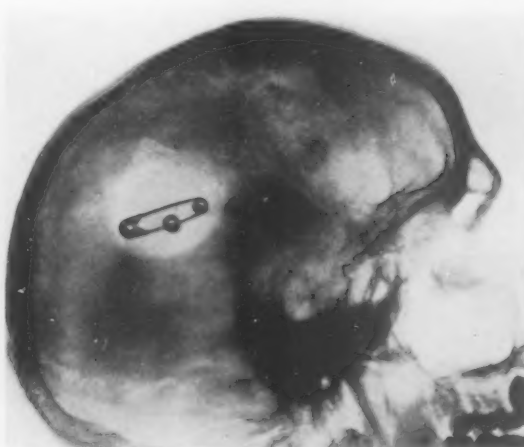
Lateral view nine days after radiographs, Figs. 10 and 11. Very little sodium iodide could be injected. However, when this is compared with the previous radiograph it will be seen that some entered the upper cavity.
